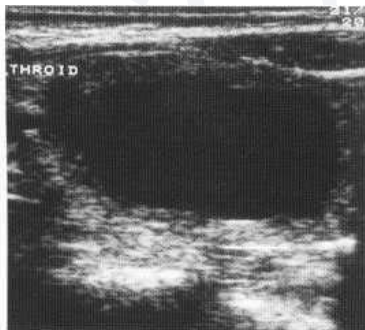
Longitudinal ultrasound scan through the left lobe of the thyroid demonstrates a simple cyst.
